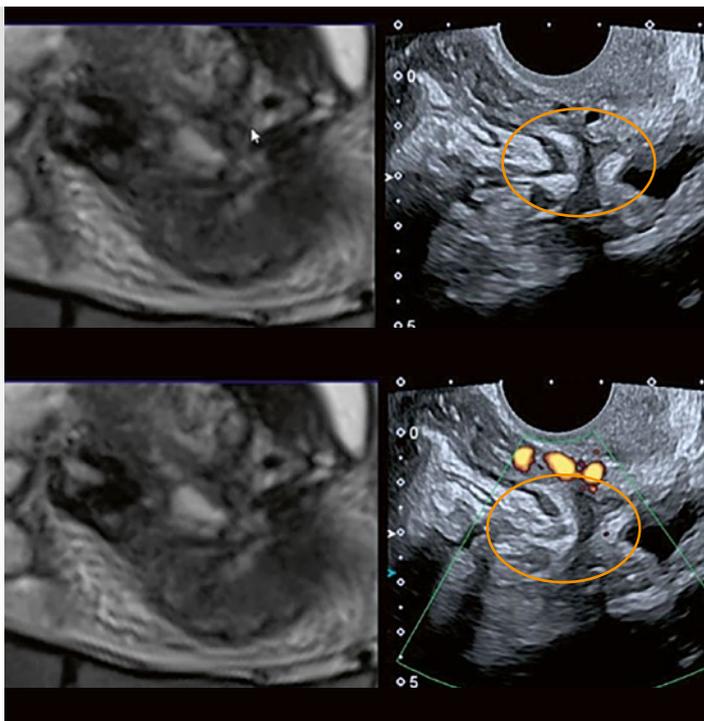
MRI/ultrasound sagittal section at the recto-uterine pouch. A posterior nodule infiltrates the anterior rectal wall.
